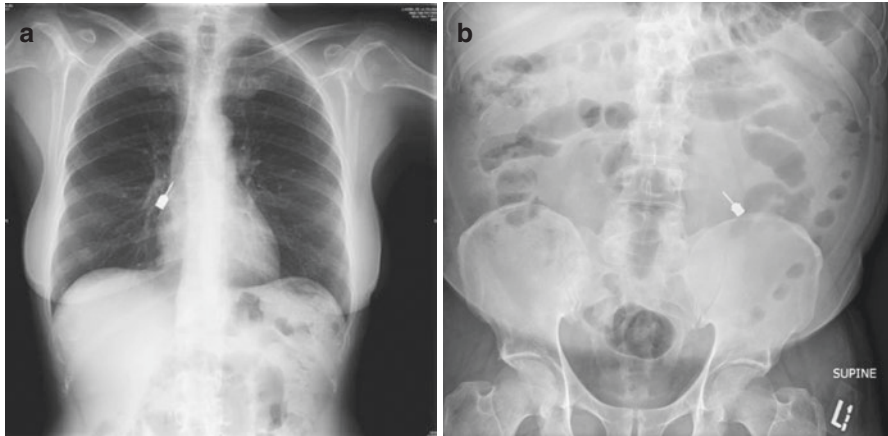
(a) A chest X-ray that demonstrates an implant driver that was aspirated into the right main stem bronchus (Taken from Pingarrón Martín, L., Morán Soto, M.J., Sánchez Burgos, R. *et al.* Bronchial impaction of an implant screwdriver after accidental aspiration: report of a case and revision of the literature. *Oral Maxillofac Surg* 14, 43–47 (2010). (b) An abdominal radiograph was taken after an implant driver was displaced into the digestive tract
